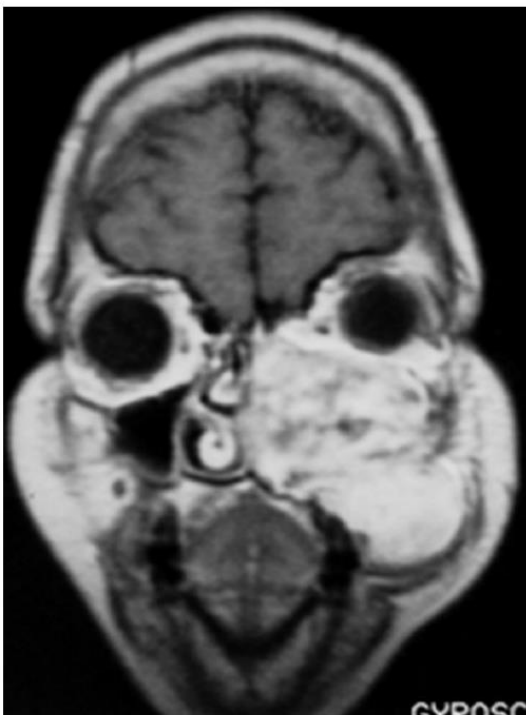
T1 post-contrast MRI displayed various patterns of contrast uptake/enhancement. Some areas of the tumor enhanced markedly and were assumed to be collagenous, the unenhanced areas being deduced as myxomatous and/or bony septae.
